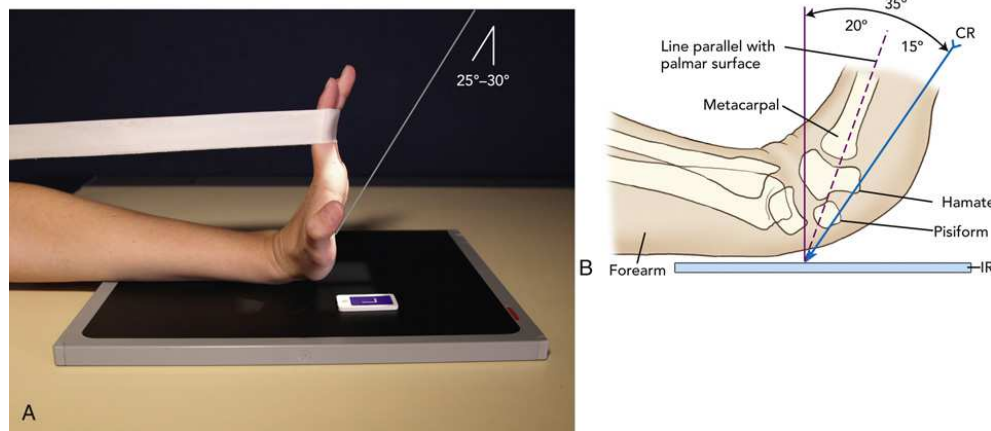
(A) Tangential (inferosuperior) carpal canal: Gaynor-Hart method. (B) Suggested CR alignment when wrist cannot be extended within 15 degrees of vertical. CR is angled 15 degrees more than angle of metacarpals. B, Modified from McQuillen Martensen K. *Radiographic image analysis*. 3rd ed. St Louis: Saunders; 2010.
